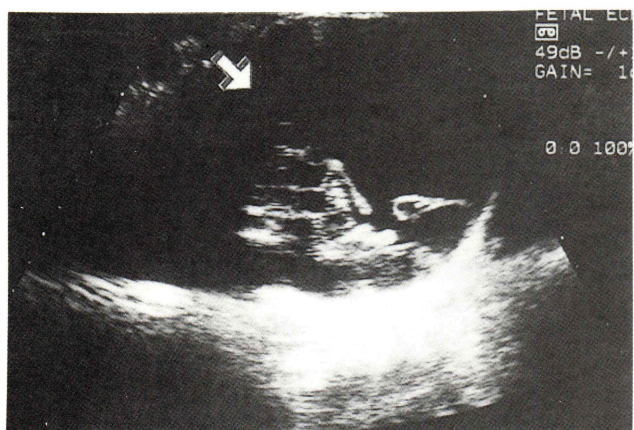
Ultrasound image of porencephalic cyst.
